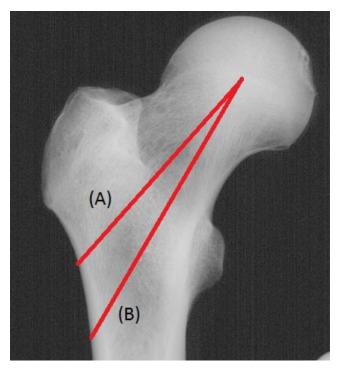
Xray of typical femur with projections of intended path for drill holes through femoral cortex. Line (A) represents a starting point at the apex of the lesser trochanter and aimed toward the center of the femoral head, and line (B) starts below the level of the lesser trochanter.
